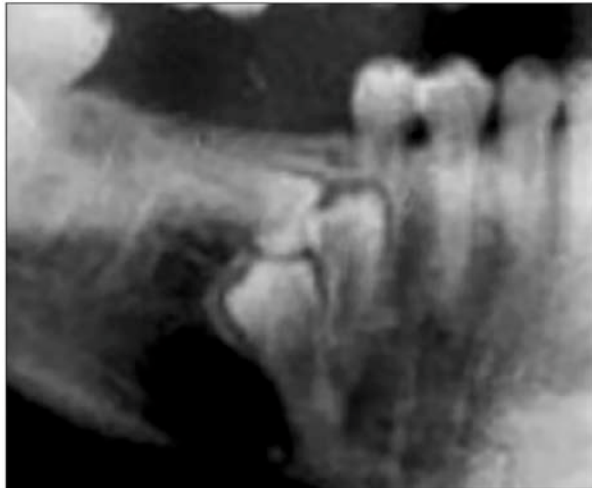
Cropped panoramic radiograph of supernumerary premolar teeth, peridons.
